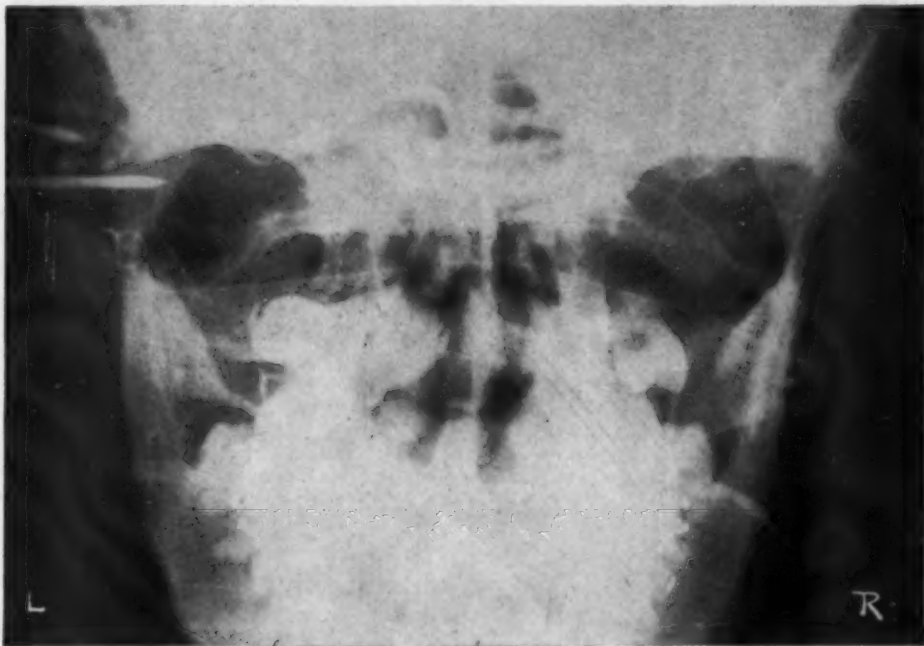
Postoperative x-ray showing skeletal and internal wiring fixation immediately after the operation.
